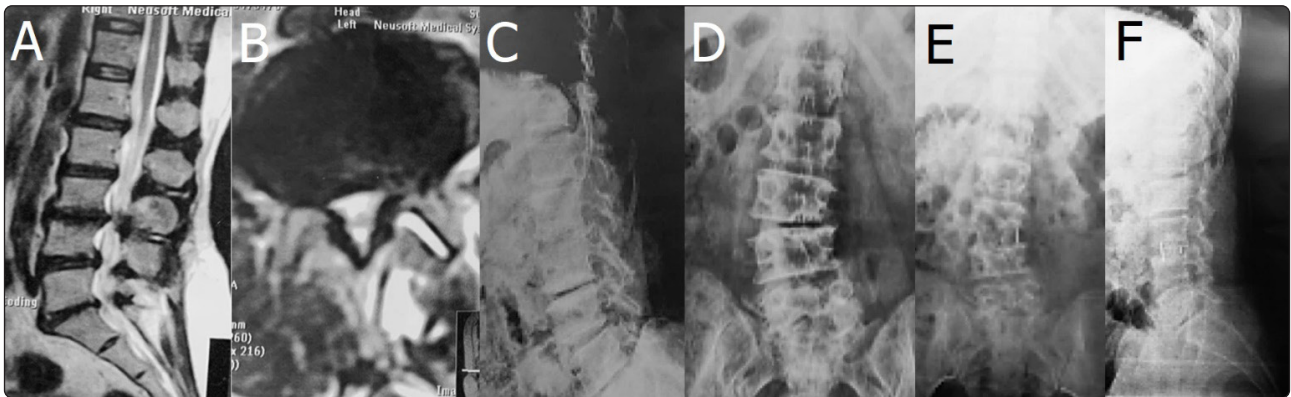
(A) MRI preoperative T2W axial cuts showing facet effusion and disc prolapse and (B) MRI preoperative T2W sagittal cuts showing canal stenosis at L3/L4 and decreased disc height. (C) Preoperative lateral lumbar X-ray showing degenerated intervertebral disc L3/L4, SVA: 10 mm, PT: 27 degrees, SS: 33 degrees, LL: 18 degrees, PI/LL mismatch: 38, and anterior disc height: 5 mm. (D) Preoperative AP lumbar X-ray shows Cobb's angle of 28 degrees, (E) demonstrates AP lumbar X-ray 1-year follow-up with corrected Cobb's angle to 7.3 degrees after stand-alone OLIF L3/L4, and (F) demonstrates lateral lumbar X-ray 1-year follow-up: SVA: 6 mm, SS: 35 degrees, PT: 25 degrees, LL 22 degrees, anterior disc height: 14 mm, and PI/LL mismatch: 35.
